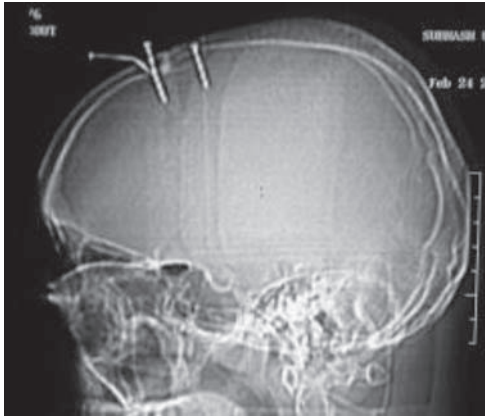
CT brain (bone window), sagittal view showing three radio-opaque nails which have penetrated both tables of skull and entered the brain parenchyma.
